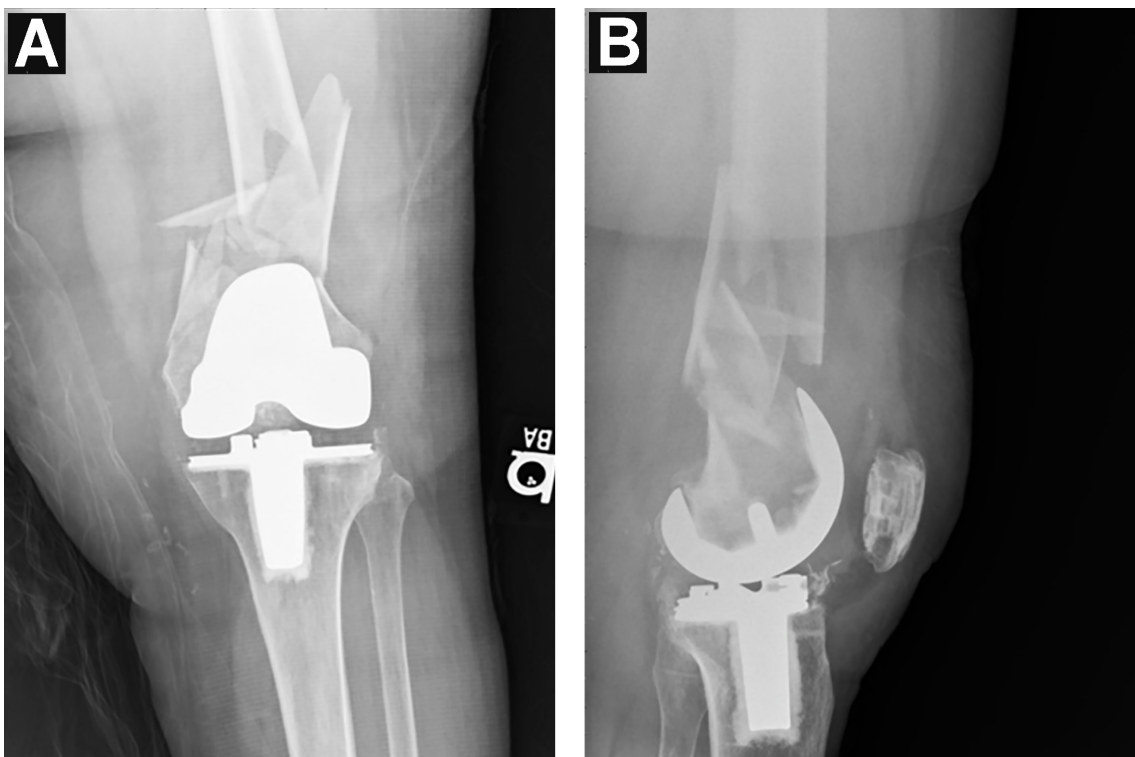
Preoperative anteroposterior (A) and lateral (B) X-rays of the left knee demonstrating comminuted distal femur periprosthetic fracture.
